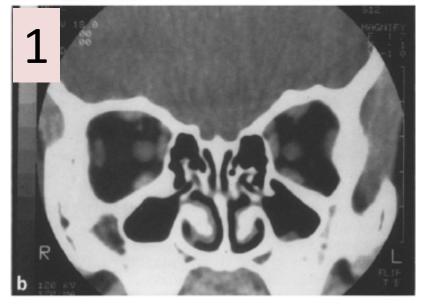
a, b. Preoperative computed tomography (CT) scan in 3-yearold patient with V-pattern strabismus. a Scout film demonstrates plane of section perpendicular to the hard palate; b coronal section just posterior to the globe. The location, relationship, and dimensions of the four rectus muscles can easily be determined
